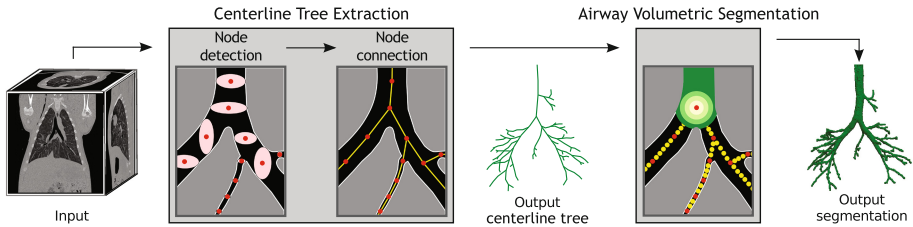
Algorithmic overview. From input CT volume, a centerline tree is extracted in two steps, followed by airway segmentation based on region growing.
